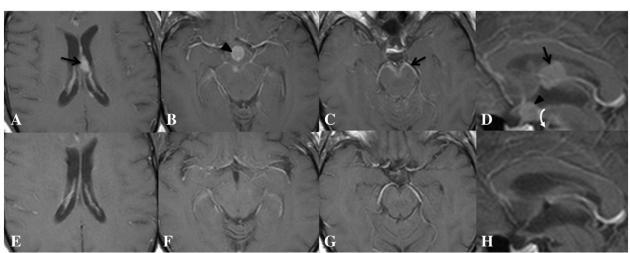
Axial (A to C, E–G) and sagittal (D, H) contrast-enhanced, T1-weighted, magnetic resonance imaging pre-chemotherapy (A–D) and post-chemotherapy (E–H). Interval disease remission demonstrated by resolution of the nodular, homogeneously-enhancing lesion centred in the septum pellucidum (A, arrow & D, arrow) and hypothalamus (B, arrowhead & D, arrowhead). Leptomeningeal enhancement encasing midbrain and interpeduncular cistern (C, arrow & D, curved arrow) is similarly resolved post-chemotherapy. Note that there is no appreciable hydrocephalus.
